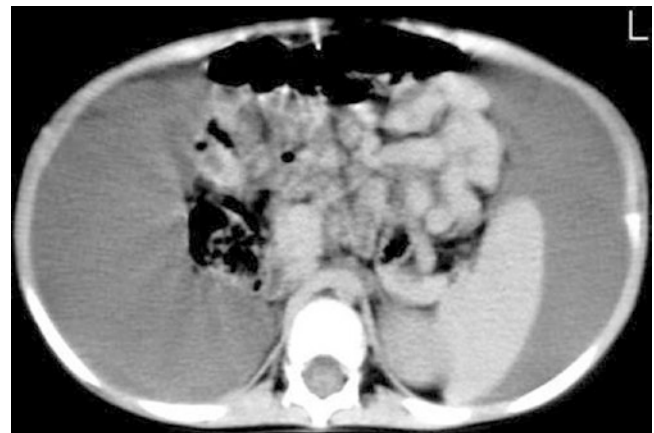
CT scan findings on a 3-year-old boy with subserosal EGE [60]. CT scan shows a massive ascites displacing the intestine in the center of the abdomen in a 3-year-old patient with serosal subtype of EGE. (From Barabino et al. [60]. Reproduced with permission from Springer Nature)
